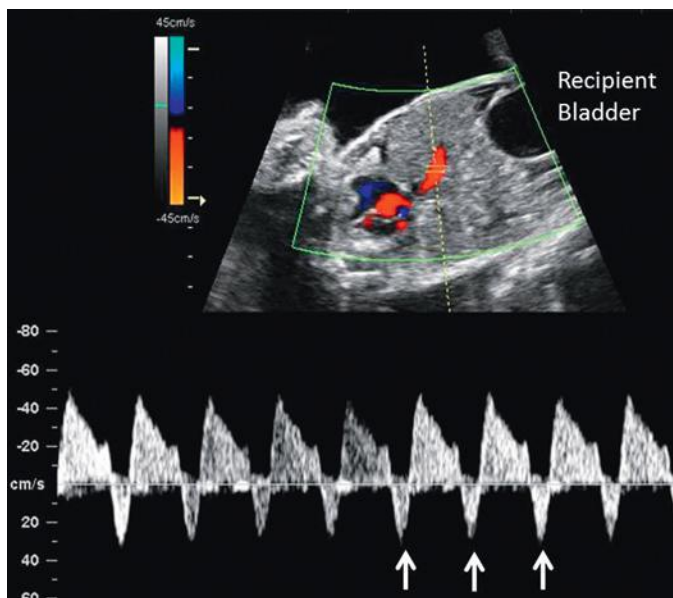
Twin-twin transfusion syndrome. Recipient twin with distended urinary bladder. Spectral Doppler waveform of the ductus venosus demonstrates reversed a-wave flow (*arrows*), indicative of cardiac diastolic dysfunction associated with overload.
